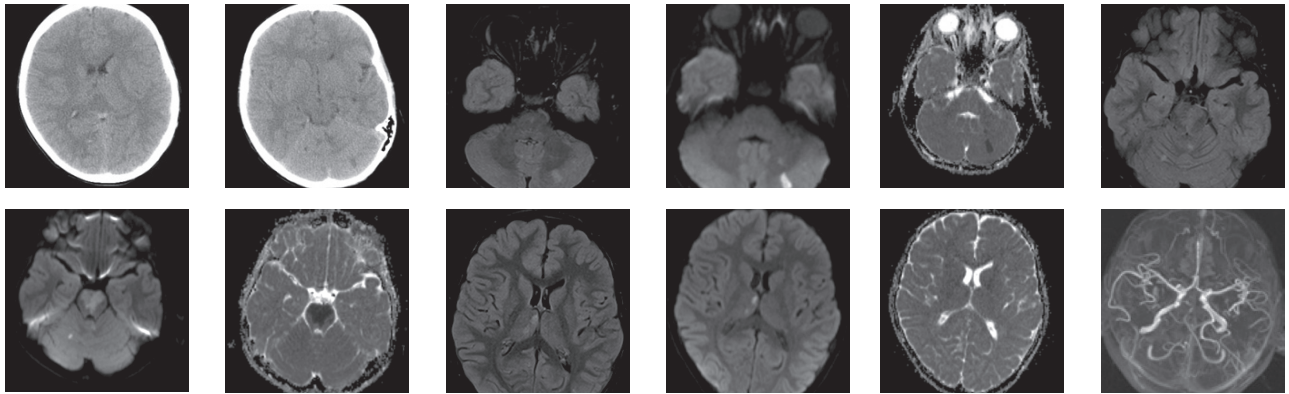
Hypodense lesions in right thalamus and cerebellar hemispheres (A, B). The MRI scan taken 24 hours later showed different time of occurrence of hyperintense lesions in T2W/FLAIR and DWI corresponding to hypointense lesions in ADC (C to K). Lack of basilar artery differentiation in TOF (L).
